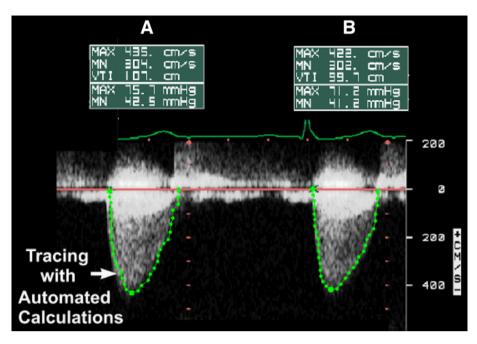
Calculation of trans-aortic gradients by continuous-wave Doppler.
